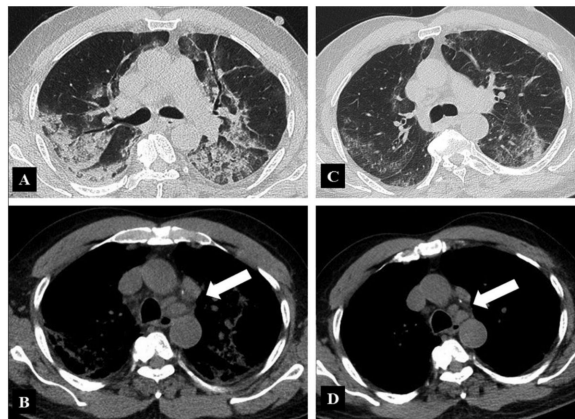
64-year-old man who received tocilizumab as a treatment of COVID-19 pneumonia. A. Unenhanced CT image of the lungs in the transverse plane obtained at day 7 shows diffuse ground glass opacities, mainly consolidations, with poorly represented ground glass opacities. The distribution is bilateral, with predominant posterior location. Linear opacities are bilateral, even if more evident on the left side. Diffuse thickening of the bronchial walls is present, as well as mild bilateral pleural effusion. B. On mediastinal window, unenhanced CT image shows mediastinal lymphadenopathy (arrow). C. Unenhanced CT image of the lungs in the transverse plane obtained at day 14 shows marked improvement of CT findings, with bilateral reduction of consolidations. Some ground glass opacities are still visible, with predominant peripheral and posterior location. Peripheral linear striped opacities are visible. D. On mediastinal window, unenhanced CT image shows mild decrease in size of mediastinal lymphadenopathy.
